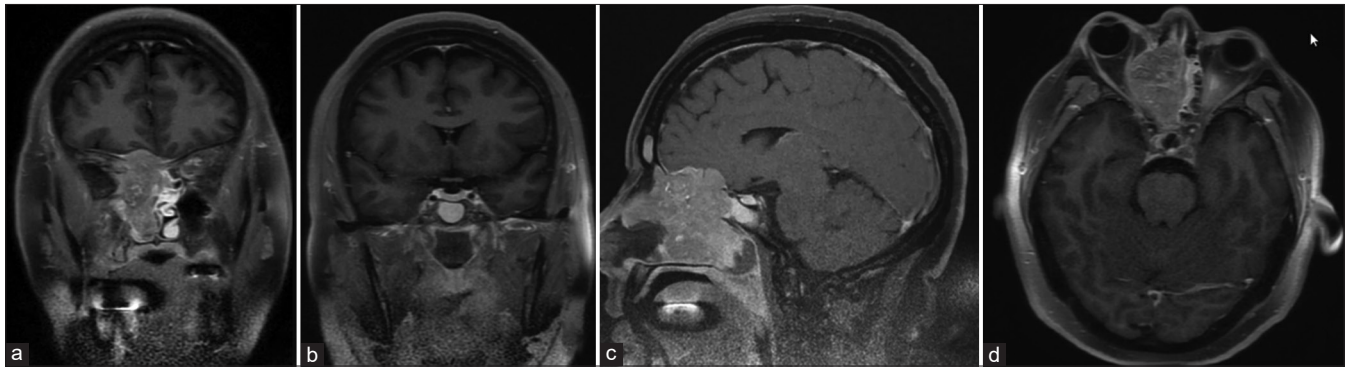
Preoperative magnetic resonance imaging. Coronal T1WI (a and b), sagittal T1WI (c), and axial T1WI. A noncalcified heterogeneous mass with origin in the right nasal cavity with irregular infiltration to ipsilateral ethmoid cells and orbit, causing nasal septum displacement and skull base erosion, with slight frontal lobe displacement can be observed. Uninvolved pituitary gland and sellar region are shown in Figure 1b.
